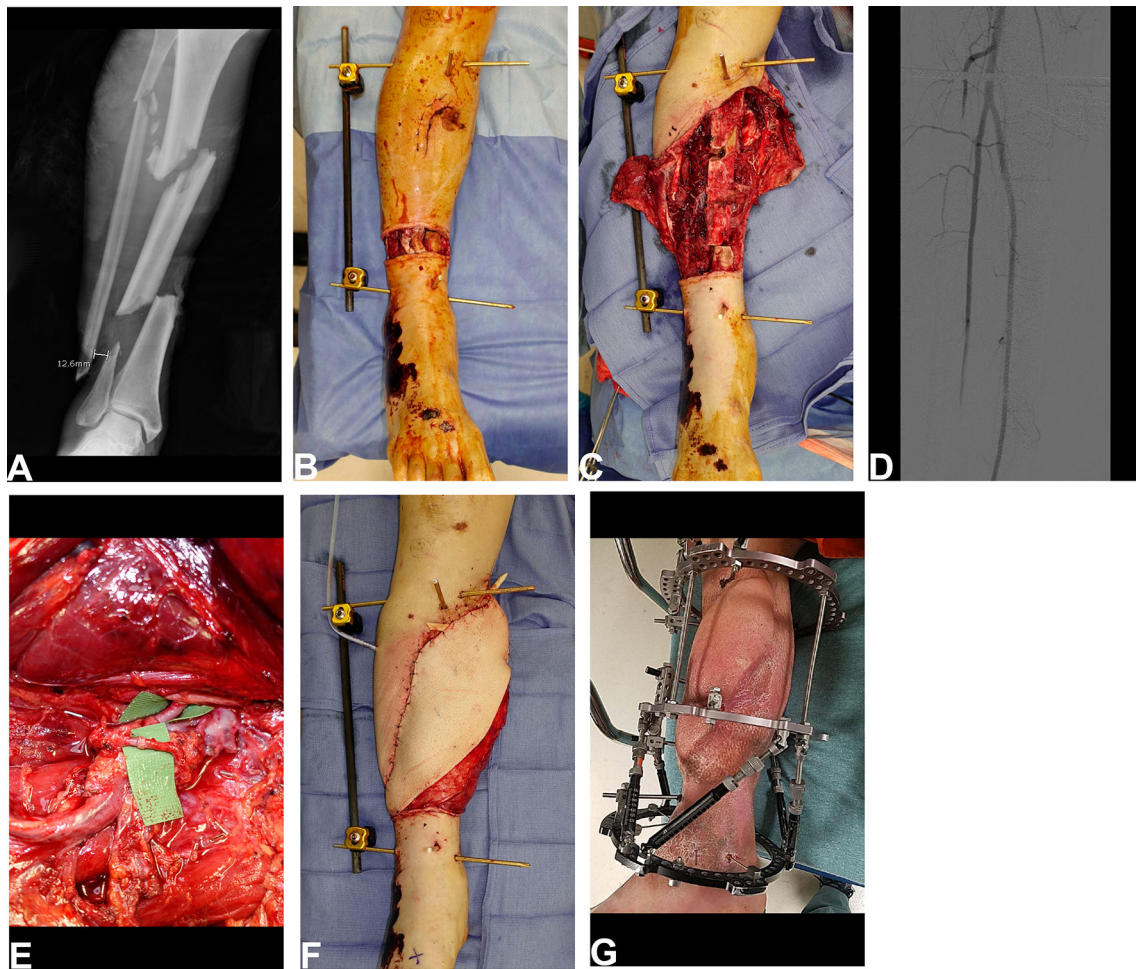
A 46-year-old male with lower extremity injury after being hit by an automobile. Radiographs revealed significantly displaced, multilevel tibia-fibula fractures (A). He underwent reduction with external fixation and aggressive debridement that produced a large soft tissue defect (B, C). Arteriography revealed a single-vessel leg (posterior tibial); however, a decision was made to proceed with limb
